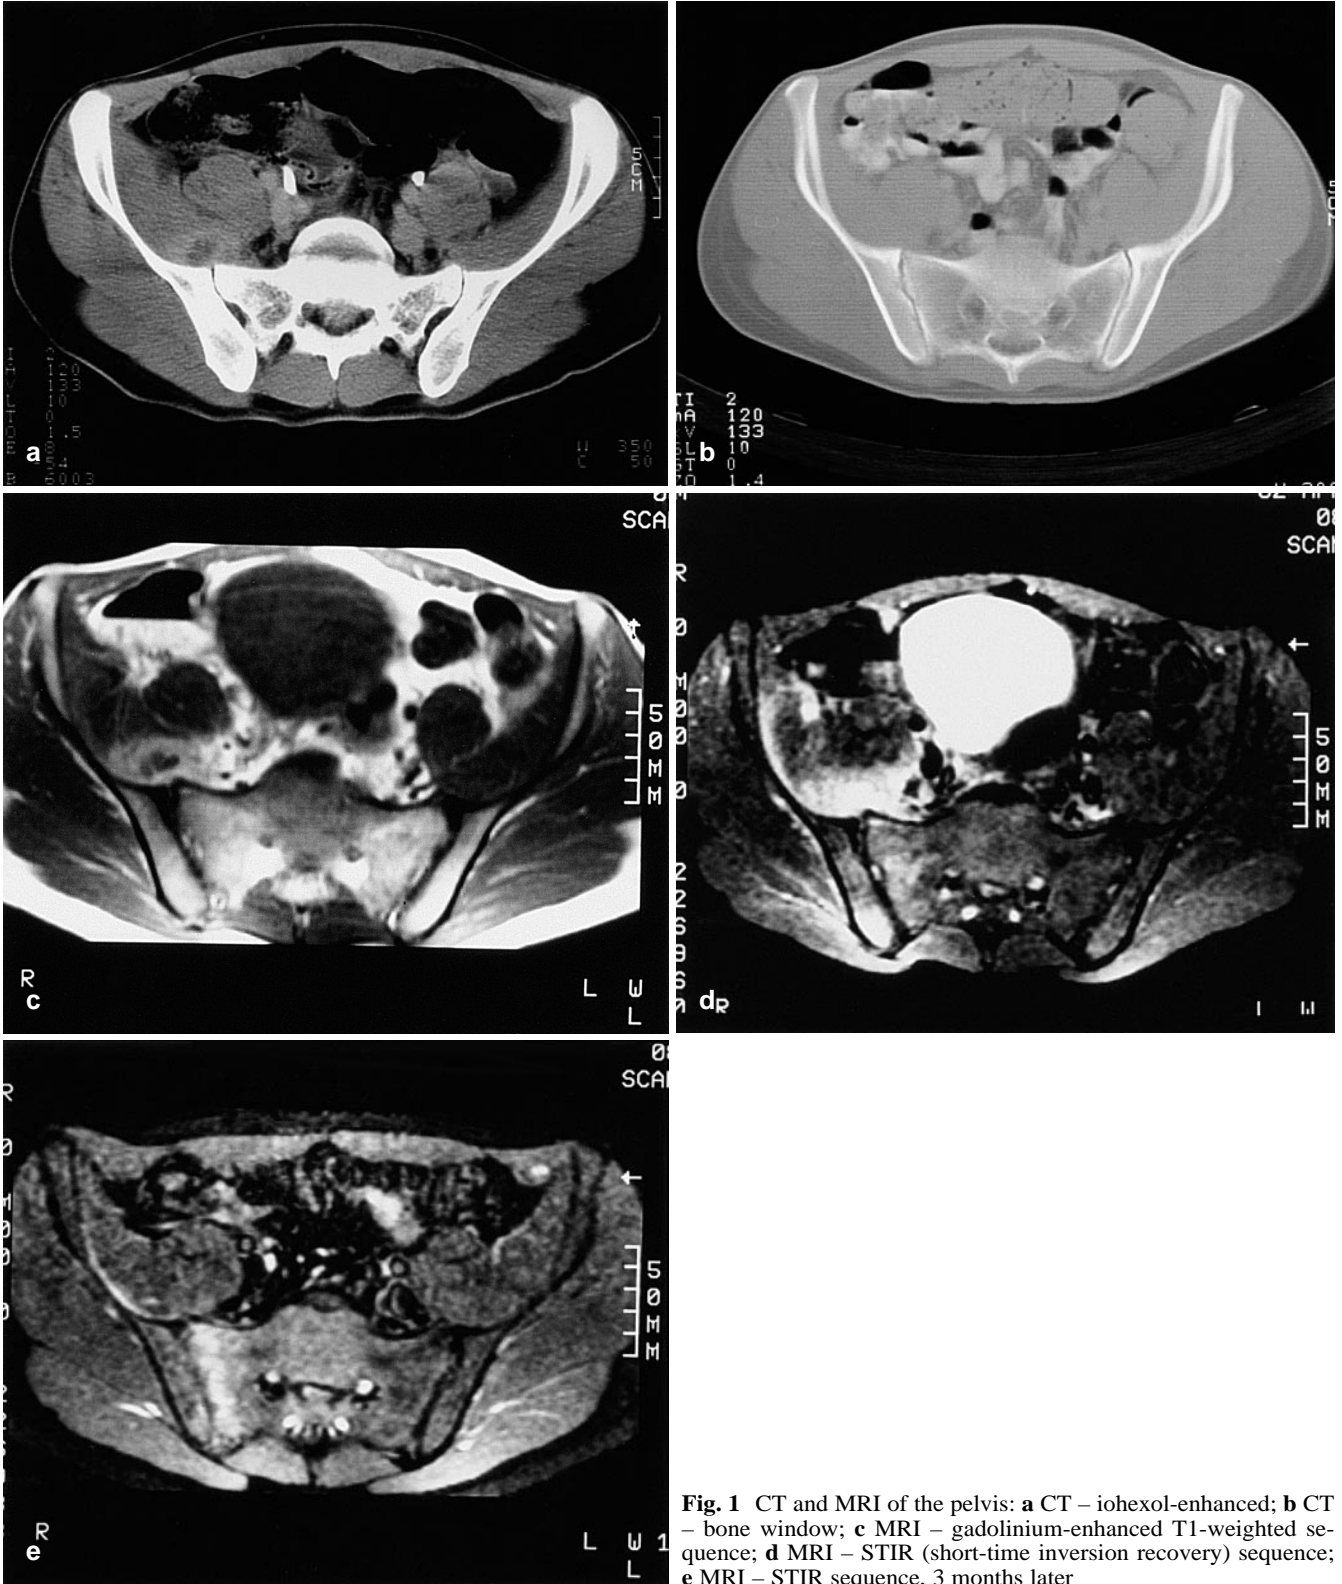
CT and MRI of the pelvis: a CT – iohexol-enhanced; b CT – bone window; c MRI – gadolinium-enhanced T1-weighted sequence; d MRI – STIR (short-time inversion recovery) sequence; e MRI – STIR sequence, 3 months later
